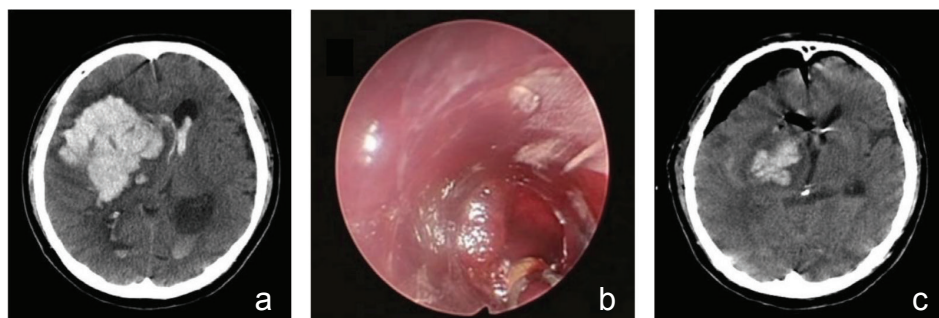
a: Preoperative computed tomography (CT) image revealing approximately 165 mL of putaminal hematoma with intraventricular hemorrhage and severe midline shift. b: Endoscopic view through a transparent sheath inserting to the hematoma cavity. c: Postoperative CT scan showing a part of residual hematoma inside of the putamen.
